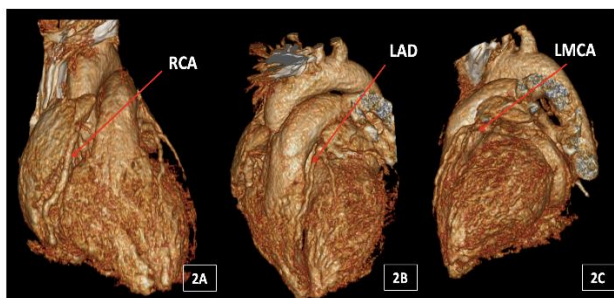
Cardiac computed tomography performed at the end of 6 months showing moderate aneurysm of RCA with a Z-score of 6.01 (2A), LAD with a Z-score of 8.82 (2B) and LMCA with a Z-score of 7.1 (2C).
